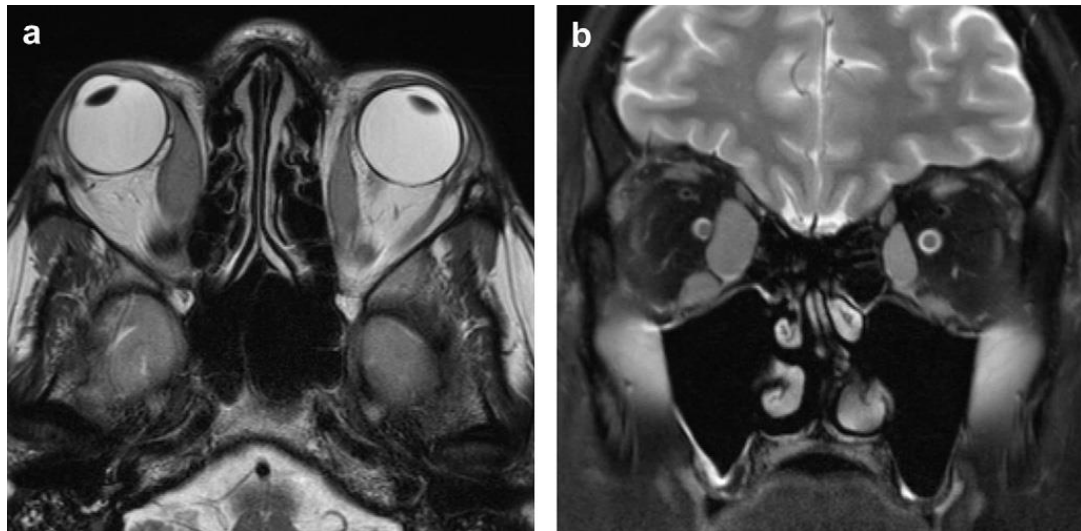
The differences between T1w and T2w in MRI of orbital tissue
